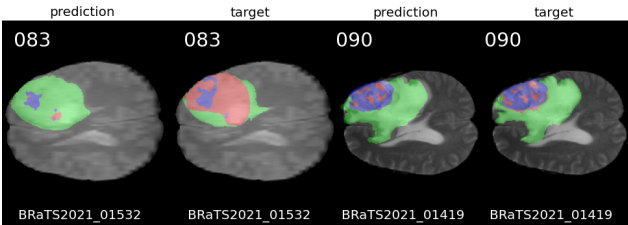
Case 01532: WT=0.9058, TC=0.4828, ET=0.3127. Case 01419: WT=0.9756, TC=0.9873, ET=0.9635. T2 MRI.
